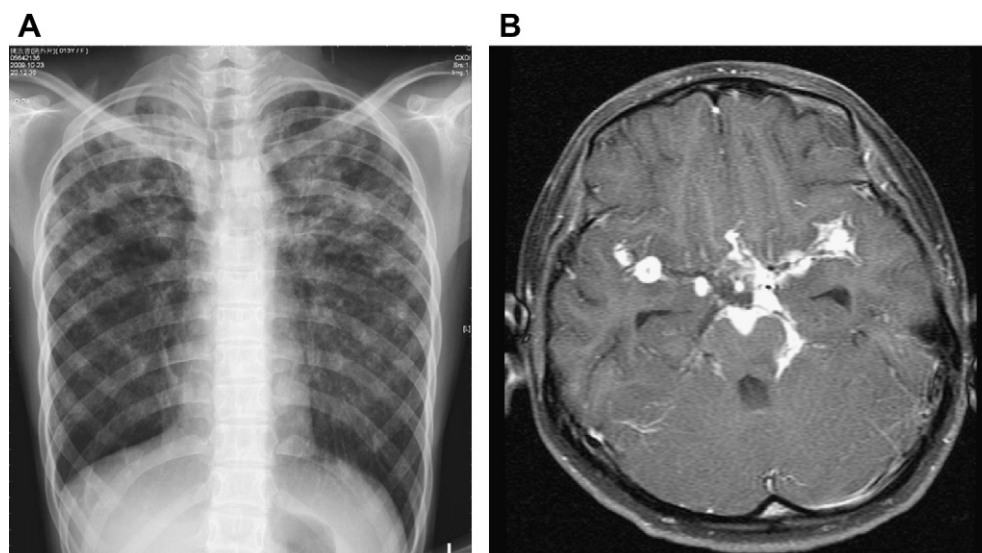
Tuberculosis (TB) involving the central nervous system (CNS). A 14-year-old girl was diagnosed with pulmonary TB 2 months before admission. She visited our emergency department because of neck stiffness and fever for 3 days. (A) Chest radiographs at admission showed patchy, poorly defined consolidation for the upper lobes, which are characteristic of secondary pulmonary TB. Sputum smears were heavily positive for acid-fast bacilli and culture positive for *Mycobacterium tuberculosis* thereafter. Magnetic resonance imaging (MRI) 2 months later showed cerebritis at left basal ganglia, left thalamus, left cerebellar peduncle, left midbrain, and left pons. (B) T2-weighted MRI showed the presence of granuloma, a so-called "paradoxical response".
